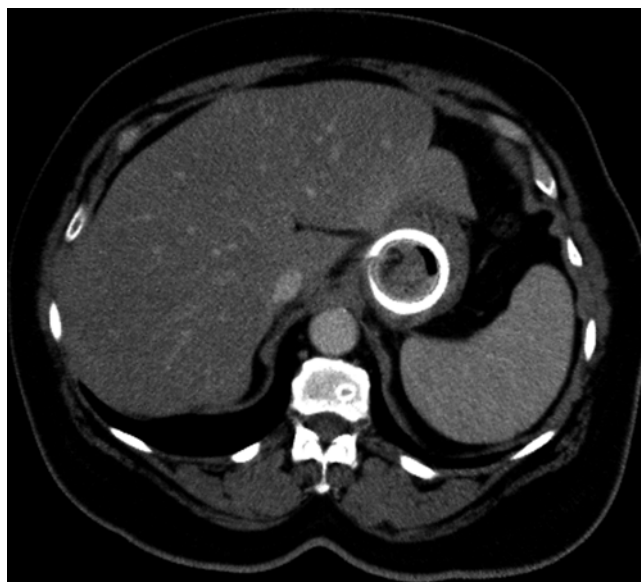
CT scan of a gastric band partially eroded into the proximal stomach
